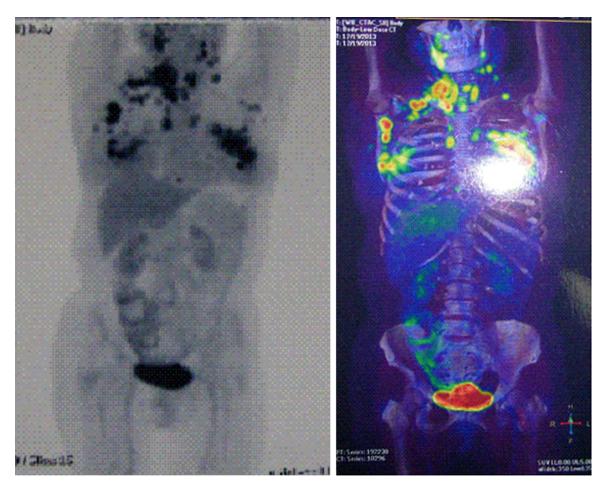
Positron emission tomography (PET) - computed tomography (CT) scan. PET - CT showed metastasis in multiple regions, including the right side of the jaw, bilateral neck, bilateral breast and bilateral armpit.
